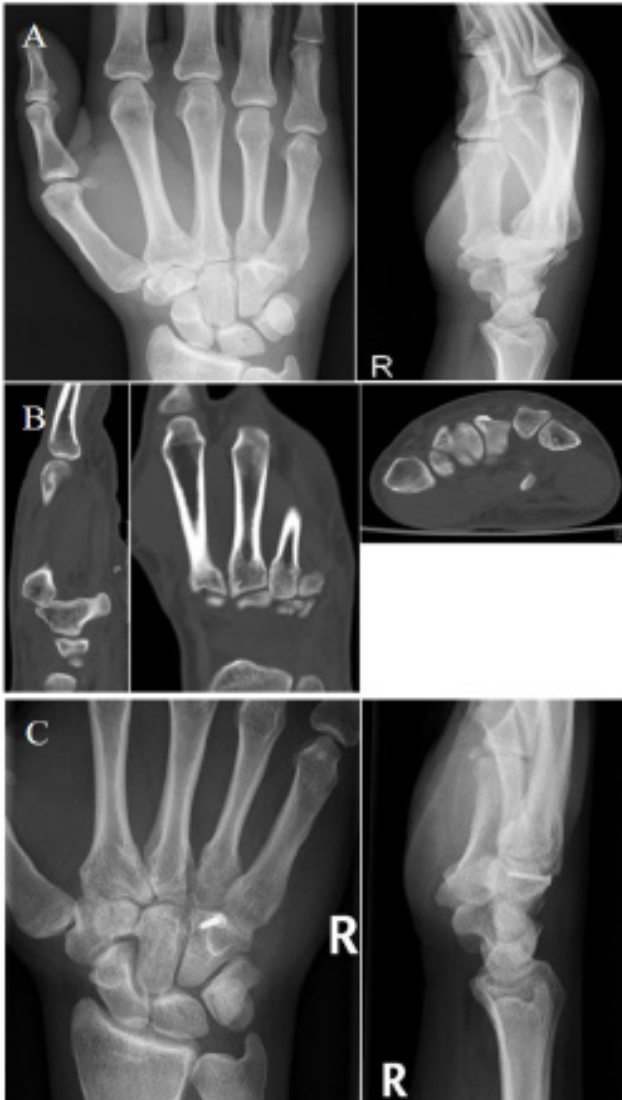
Radiographic images of case 2 – A. Radiographs after trauma showing dislocation of CMC four and five. B. Computed Tomography showing a longitudinal fracture of the hamate with dislocation of CMC four and five. C. Radiographs after open reduction and internal fixation, the hamate was reconstructed with a plate screws.
